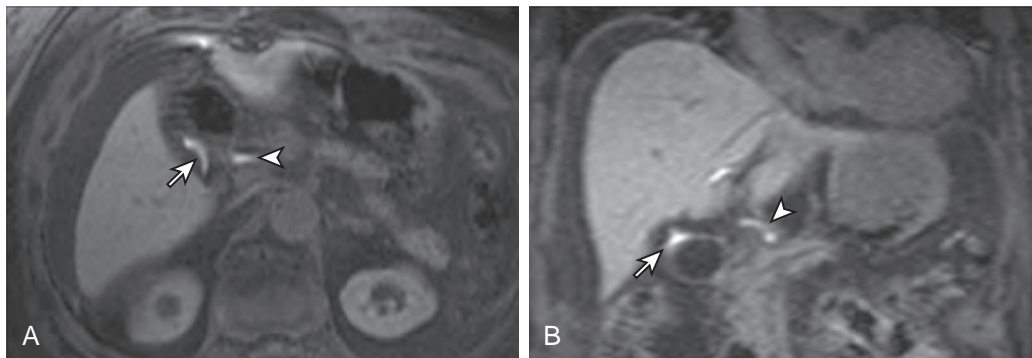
Use of MRI in demonstrating biliary leak with Eovist contrast agent. A. Axial T1-weighted fat-saturated MR image in the delayed hepatobiliary phase of enhancement reveals excretion of contrast material in the bile duct (arrowhead). A second area of excretion is seen in the gallbladder fossa, which is nonanatomic (arrow). B. Coronal T1-weighted fat-saturated image from the same examination shows the biliary excretion into the common bile duct (arrowhead) and the other area of excretion (arrow) that represents a biliary leak.
